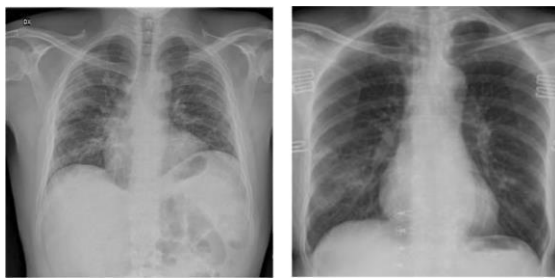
Representative chest X-ray images of COVID-19 patients[23].
